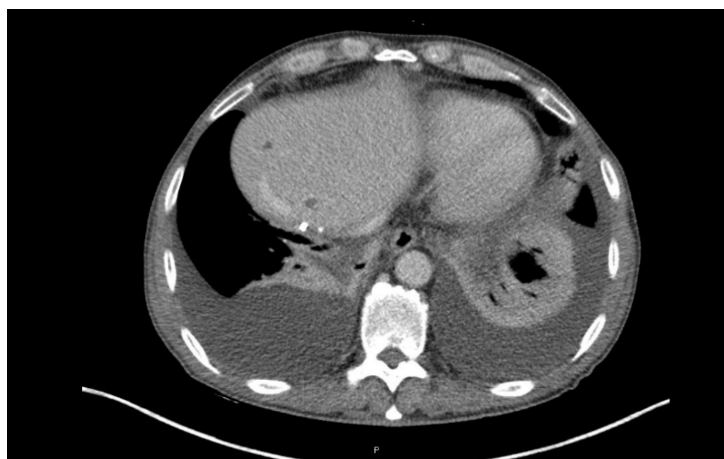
Computed tomography scan performed after four cycles of albumin-bound paclitaxel, where a mixed response was observed.
